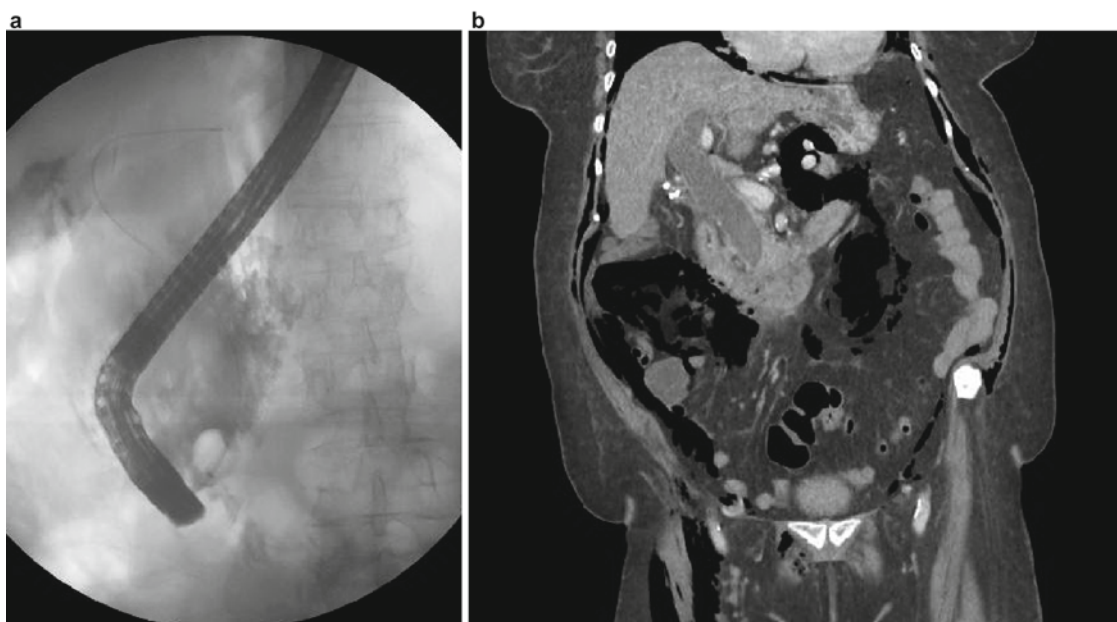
Periampullary perforation after ERCP. Extraluminal air noted after ERCP with difficult stent placement attempt. Initial cholangiogram demonstrated contrast outside of the bile duct. (a) Periampullary perforation was suspected. The patient was stable without signs of systemic illness. CT scan done for abdominal pain about 6 h after ERCP demonstrated large volume of extraluminal air but minimal fluid.
